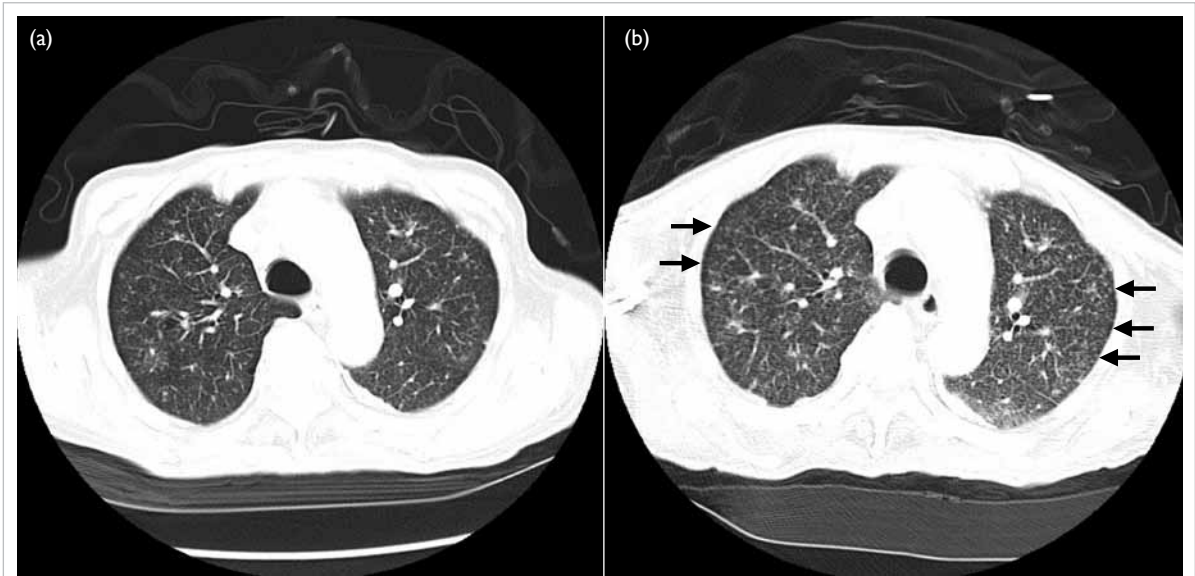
Computed tomography thorax (lung window) of the upper lobes taken (a) 2 months earlier and 2 months later are shown; an increase in micronodules (arrows) was evident in (b) as compared with (a)
